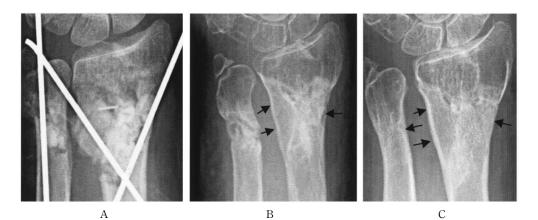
Postoperative radiologic evaluation of β -TCP (severely comminuted distal radius fracture in a 78-year-old woman)²⁰. A. Immediately after surgery. Both the dorsal and palmar bone cortices were severely comminuted, and β -TCP was used to fill fracture voids of the radius and ulna. B. Radiograph 4 months after surgery shows that the grafted β -TCP has biodegraded from its periphery and that disrupted cortical bone has been restored (arrows). C. The grafted β -TCP was almost completely bioresorbed, and the cortex (arrows) and cancellous bone were reconstructed by bone remodeling 1 year after surgery.
